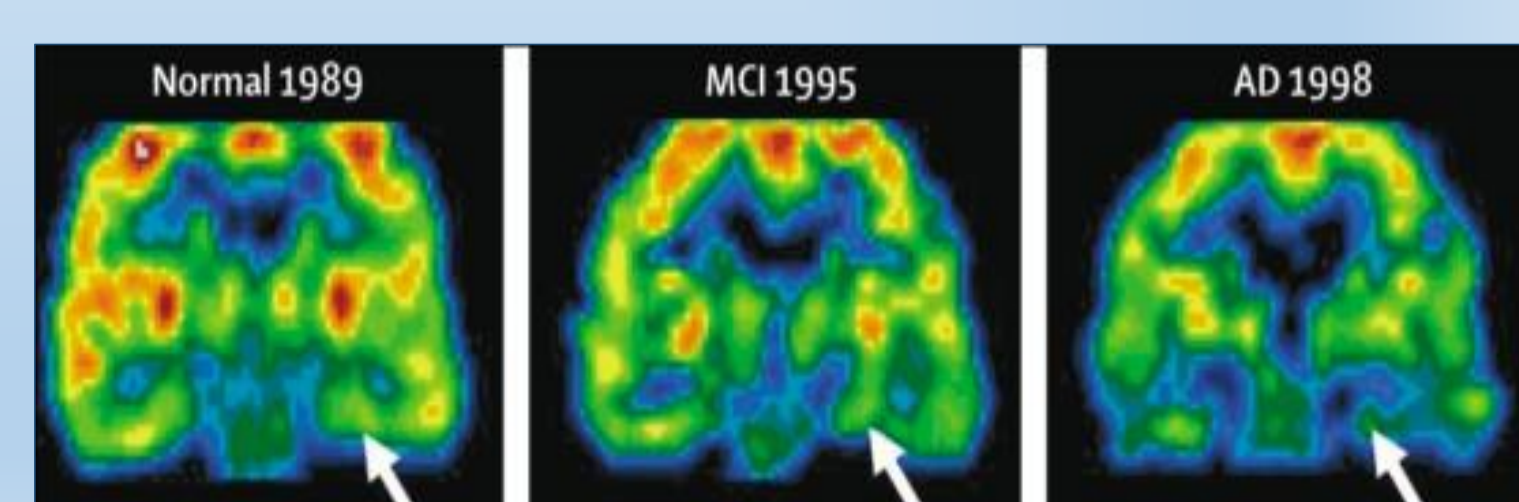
Longitudinal metabolic reductions on FDG-PET. [5]
